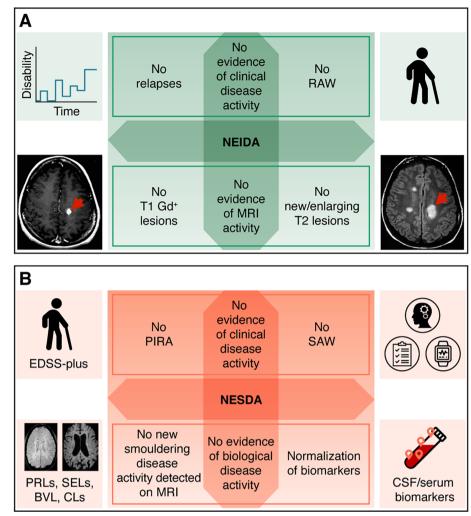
Therapeutic control of disease activity parameters in multiple sclerosis. In addition to preventing mechanisms underlying RAW, preventing smouldering pathological processes underlying SAW will become the dominant goal of future therapeutic strategies. (A) NEIDA is defined by the lack of new relapses (RAW) and of new magnetic resonance imaging (MRI) activity; (B) no evidence of smouldering disease activity (NESDA) is the defined by lack of clinical evidence of SAW, including PIRA. Changes related to SAW can be measured with cognitive tests (SDMT), PROs, stress tests, fatigue scales, wearable devices (digital markers), imaging biomarkers (SELs, PRLs, CLs, and brain atrophy), CSF/serum biomarkers (NfL, GFAP, CHI3L, and CXCL13 levels). NEIDA, absence of clinical (relapses) and MRI (newT2/GAD+ lesions) focal inflammatory activity. 9HPT = 9 holes pegs test; CHI3L1 = chitinase 3-like 1; CLs = cortical lesions; CXCL13 = chemokine ligand 13; EDSS = Expanded Disability Status Scale; GFAP = glial fibrillary acidic protein; NEIDA = no evidence of inflammatory disease activity; NESDA = no evidence of smouldering disease activity; NfL = neurofilaments light; PIRA = progression independent of relapse activity sustained progression measured by EDSS and EDSS-Plus (worsening on EDSS, T25FW or 9HPT); PROs = patient-reported outcomes; PRLs = paramagnetic rim lesions; RAW = relapse associated worsening; SAW = smouldering associated worsening; SDMT = single digit modality test; SELs = slowly expanding lesions; T25FW = timed 25 feet walking tests.
